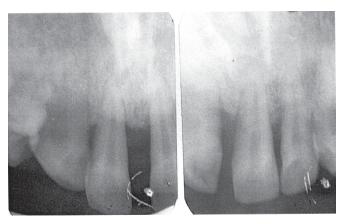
Post-operative radiograph showing appreciable bone regeneration after one year
